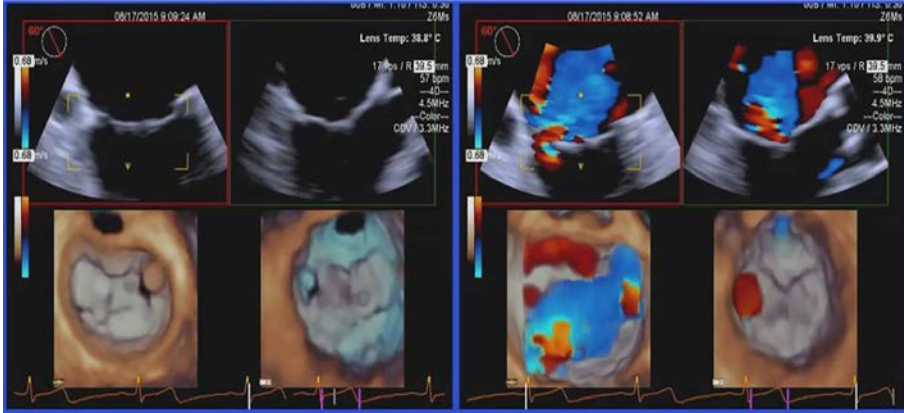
Examples of 2-D TEE (top left) and 3-D TEE (bottom left). (Top right) Colour Doppler superimposed on the 2-D images and demonstrates mitral valve regurgitation. (Bottom right) 3-D representation of the mitral valve and the associated regurgitant jet.
